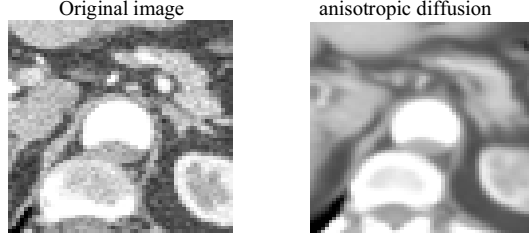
Example showing the effect of smoothing by anisotropic diffusion on a CTA slice section.
